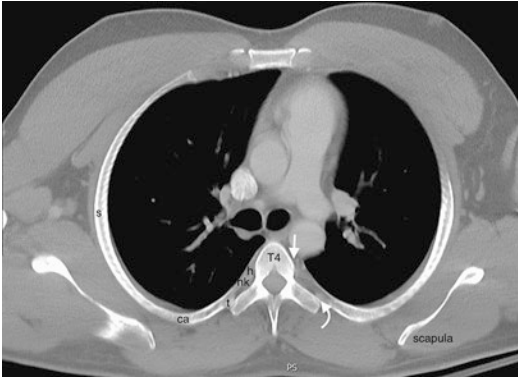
Anatomy of a true rib. Axial CT image reconstructed in the oblique axial plane at the T4 level shows the anatomic parts of a single (fourth) rib. The rib head (*h*) articulates with the vertebral body at the costovertebral joint (*arrow*) and the rib tubercle (*r*) articulates with the vertebral transverse process at the costotransverse joint (*curved arrow*). The neck of the rib (*nk*) is located between the head of the rib and the tubercle. The shaft (*s*) or body is the longest part of the rib. The posterior curve of the rib is referred to as the costal angle (*ca*). Note that at the level of the upper thoracic spine, the scapula may limit access to the lateral rib from a posterior approach
